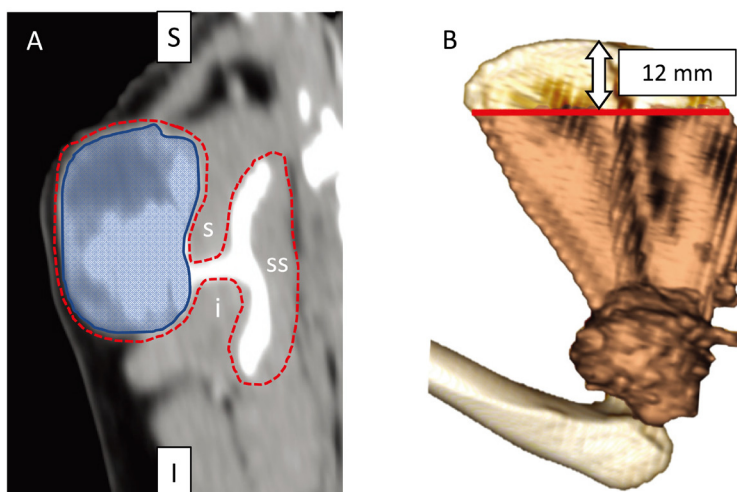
The red dotted line in a coronal section image (A) describes the area of resection (Blue area: osteosarcoma, s: supraspinatus, i: infraspinatus, ss: subscapularis muscle). Three-dimensional computed tomography image of the right scapula (B) describes the position of osteotomy (white arrow).
